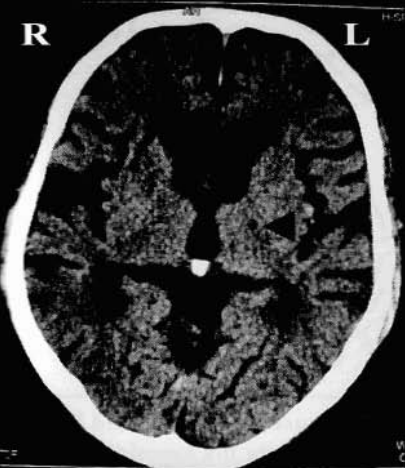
Repeated CT brain showed a hypodense area (< 15 mm in diameter) at the left internal capsule (black arrowhead).
